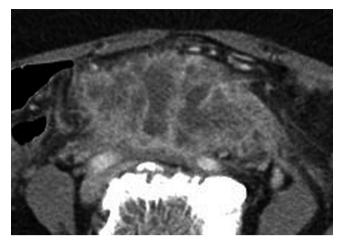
Mesenteric inflammatory pseudotumor in a 71-year-old woman who presented with abdominal pain. Axial post-contrast CT demonstrates a heterogeneously enhancing mass with spiculated margins in the small bowel mesentery.
